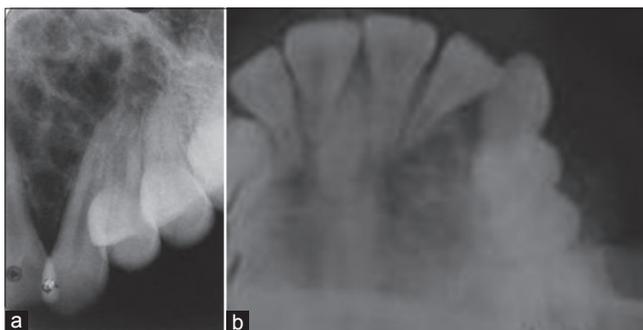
(a) Intraoral periapical radiograph showing mixed radiodensity in 22, 23 region with root divergence. (b) Occlusal radiograph showing root divergence & mixed radiodensity in 22,23 region
